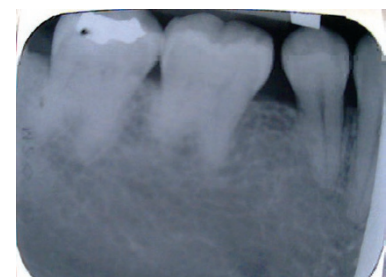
Radiograph of a young adult male showing short roots
